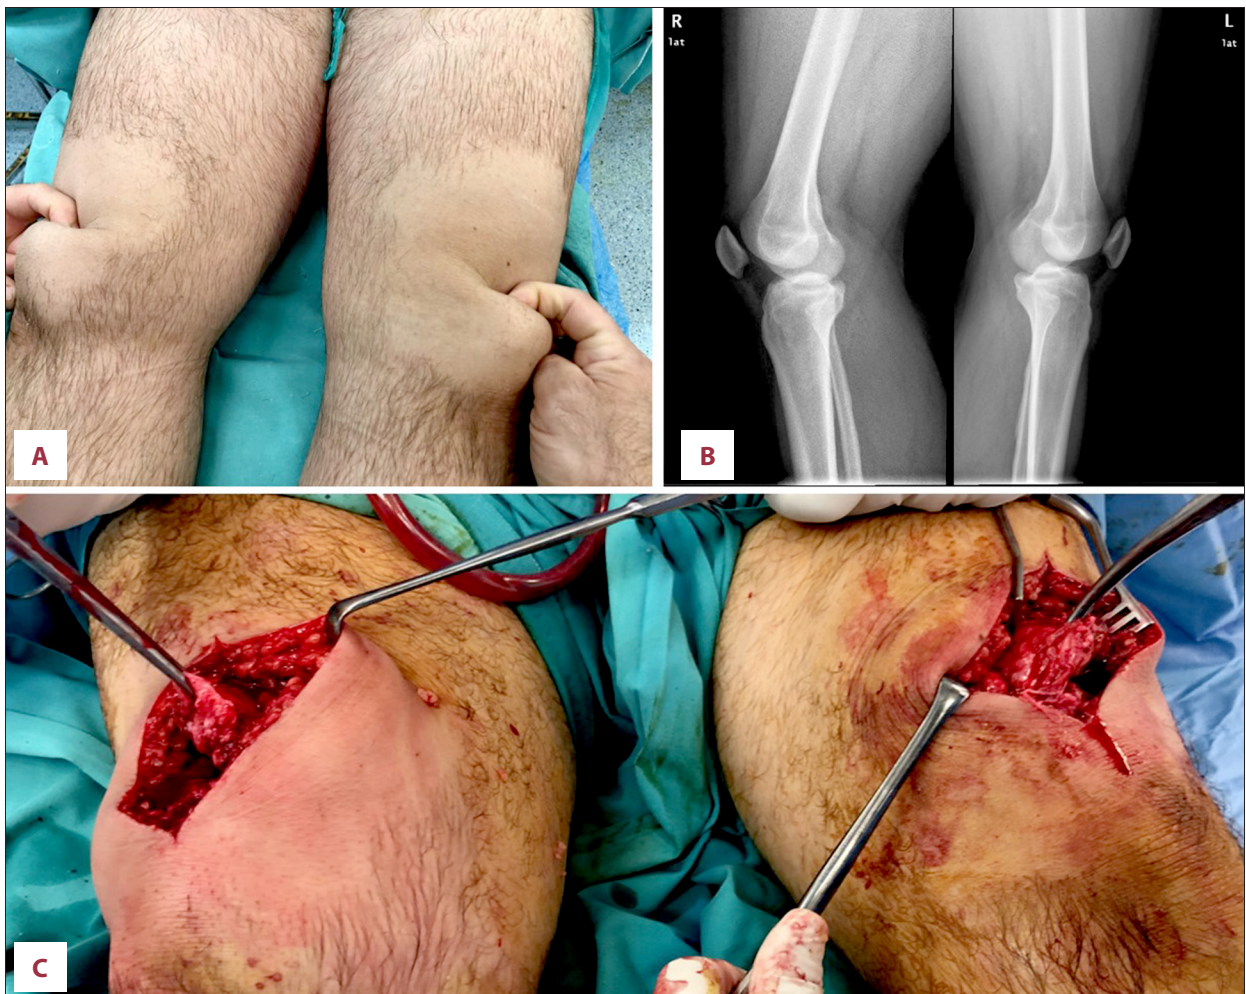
(A) Intraoperative clinical picture demonstrating bilateral suprapatellar gap due to complete disruption of quadriceps tendons at bone interface, (B) lateral radiographs showing patella baja, without evidence of tendinitis or spur formation, (C) intraoperative picture showing bilateral quadriceps rupture.
